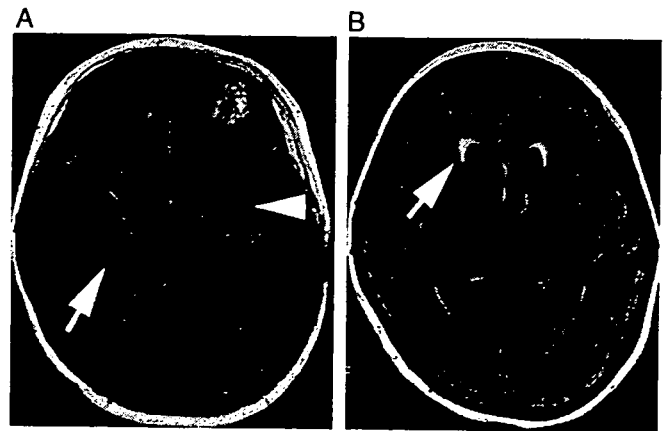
Axial FLAIR images (TR/TE/TI 8002/104/2000 ms), using a 1.5 T imager, on day 101 showed high signal lesions in both hippocampi (arrow), amygdalae (arrowhead) (A) and ventricular rims (arrow) (B). Cerebellar and cerebral atrophy were evident.
